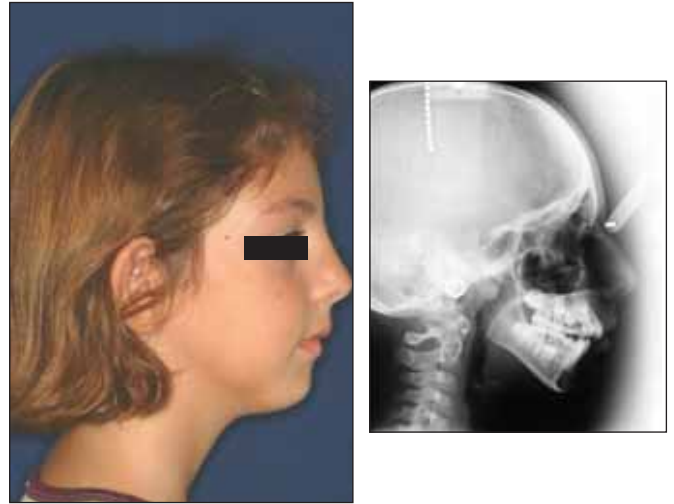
The profile view of the patient and the lateral cephalometric radiography at her initial admittance.
